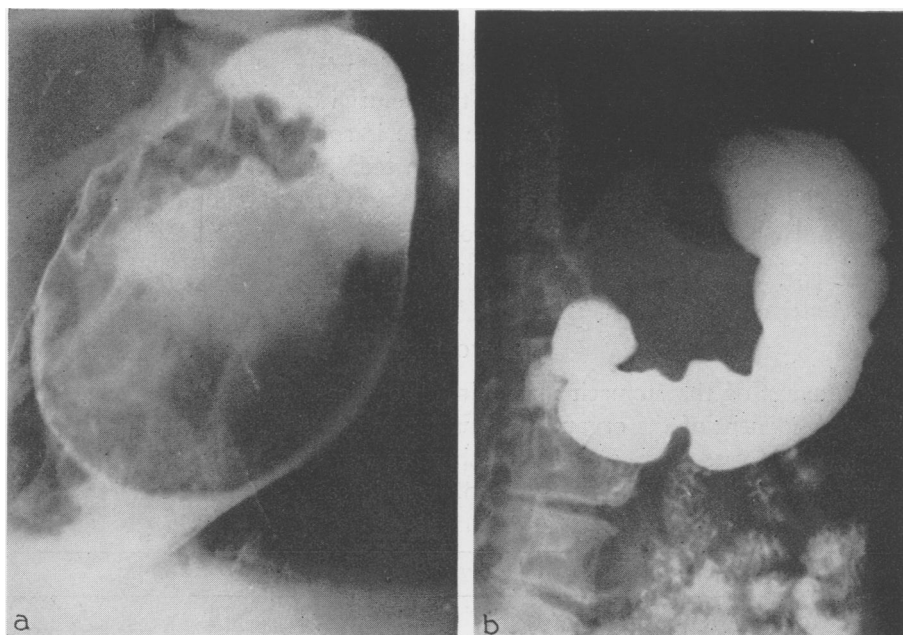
Leiomyosarcoma. (A) Intraluminal mass filling upper media and cardia; pedicle in upper cardia; transgastric excision performed. (B) Postoperative roentgenogram showing normal appearance.
